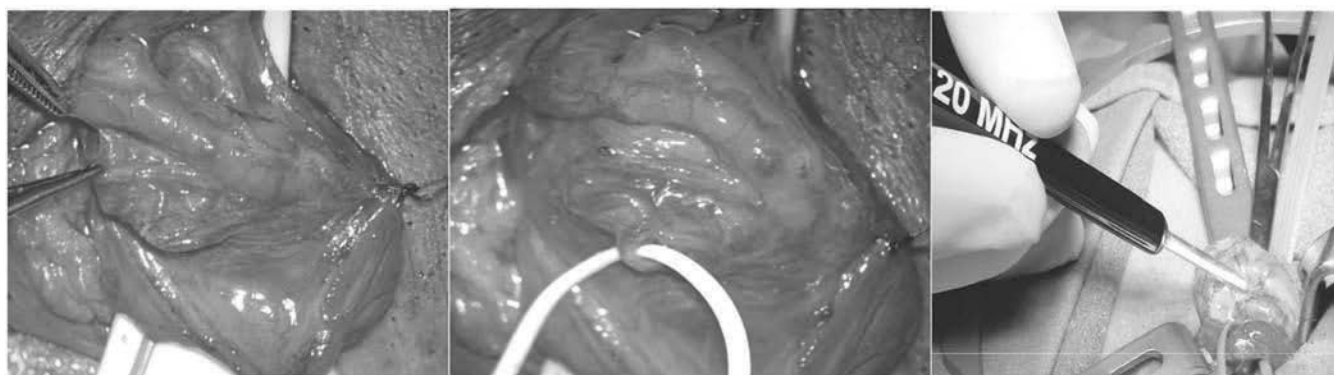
The cord is inspected for visible arterial pulsations under $\times 25$ magnification., along with a microprobe 20 mHZ Doppler. Suspected arteries can also be tested by elevating them until they are near-occluded, and then slowly lowering them until pulsatile blood flow is noted to have been reestablished. Once identified and dissected free, the arteries are encircled with small vessel loops
